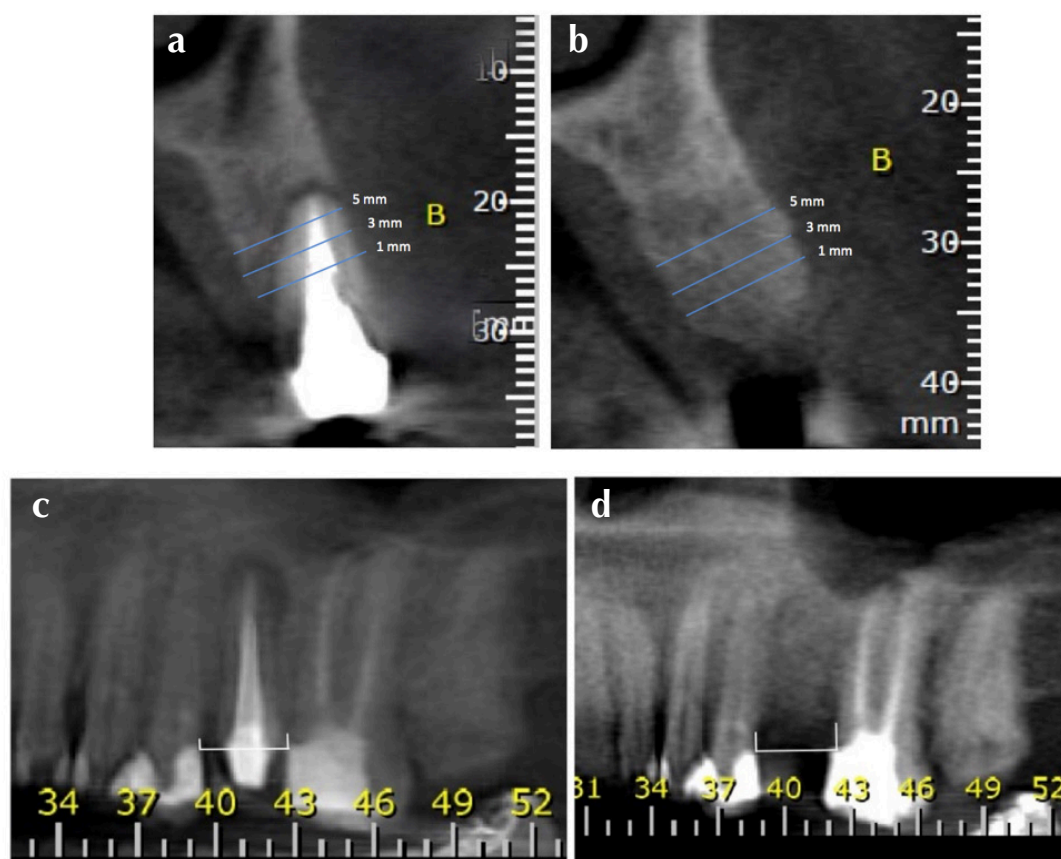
Cone-beam computerized tomography (CBCT) images taken at baseline (A&B). For the tooth to be extracted, the distance between the mesial and distal alveolar bone crest and one fixed point in an adjacent tooth (e.g., cemento-enamel junction, margin of a prosthesis) was determined at baseline (T1) and 6 months post-extraction (C & D).
